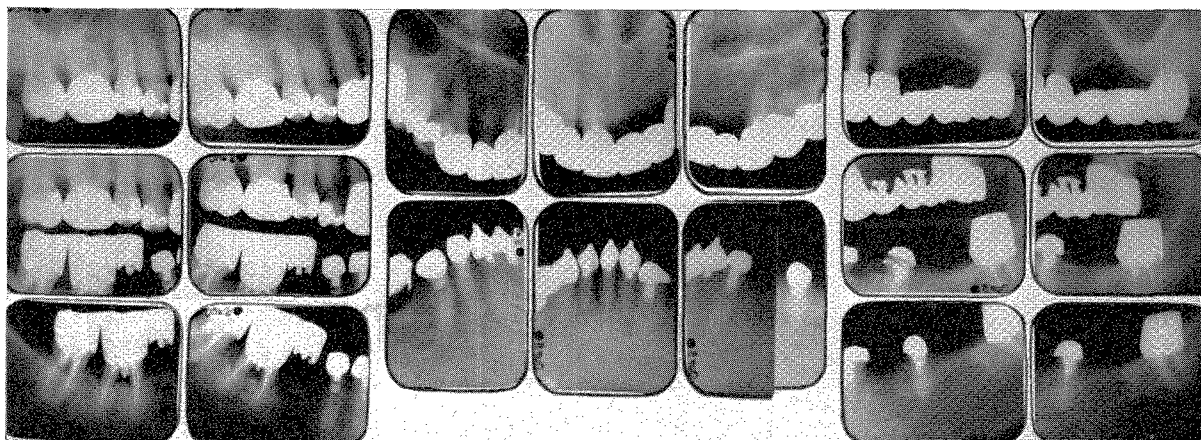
Roentgenograms taken in December, 1958, at the age of 67. Four teeth were lost since the 1952 roentgenograms.
